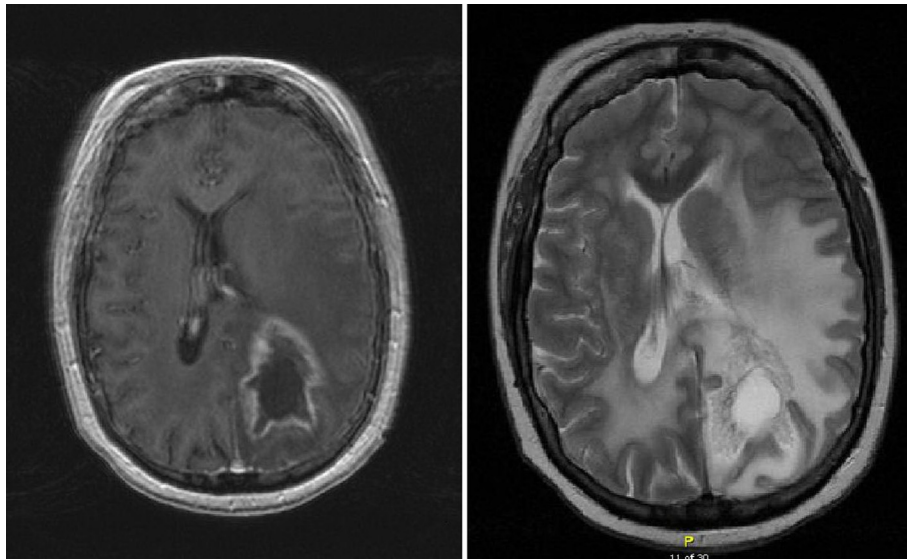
Preoperative MRI brain (T1W and T2W) showing left parietal tumor with significant perilesional edema.
